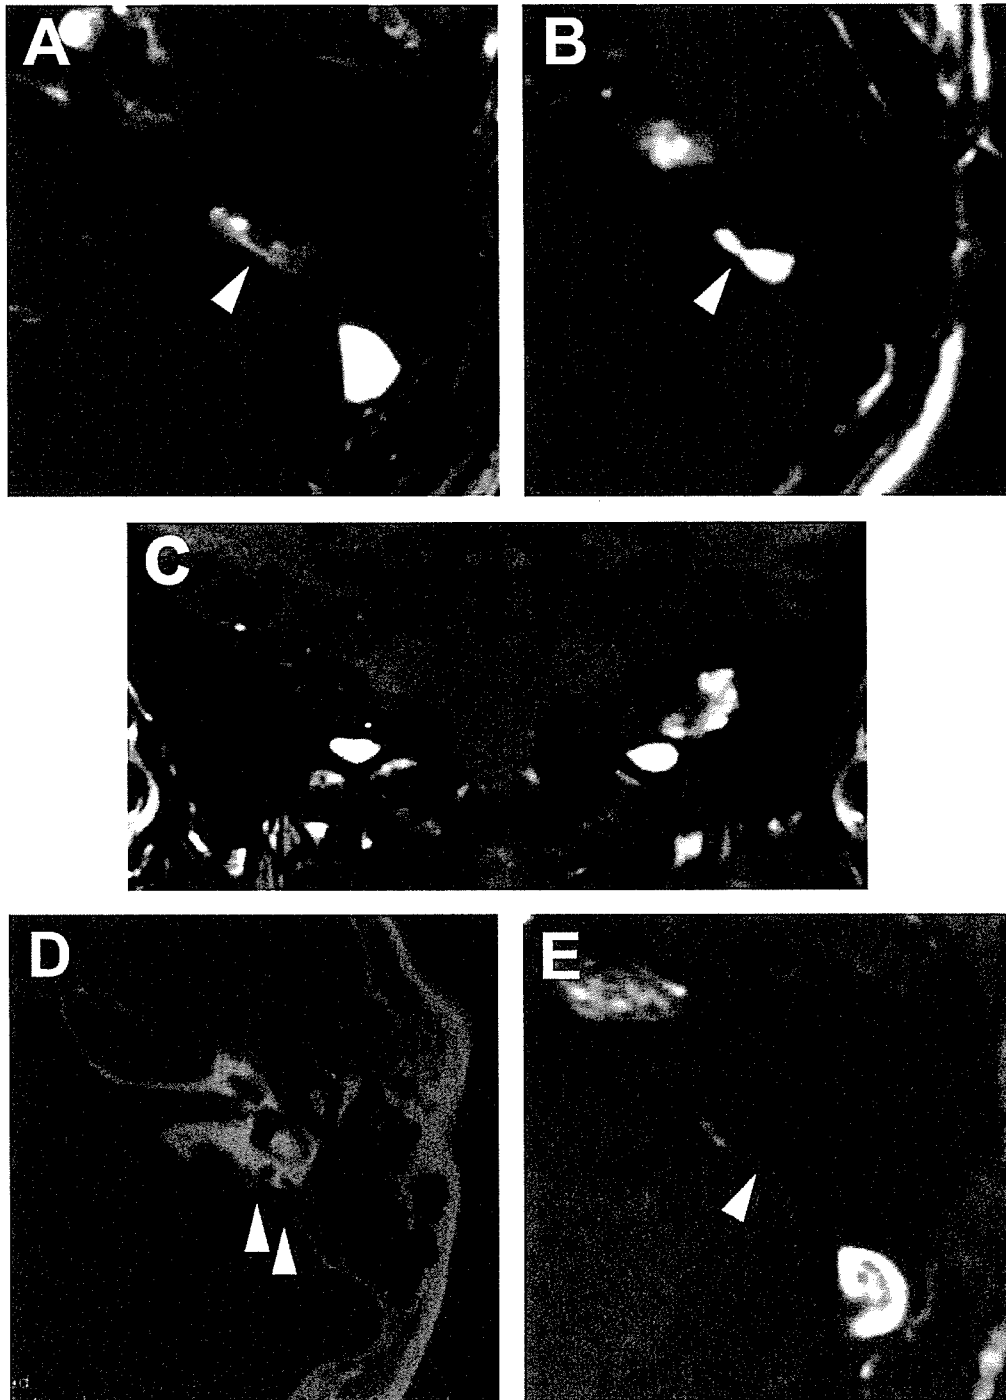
Magnetic resonance (MR) and computed tomography (CT) images of the tumor. Axial T1-weighted (A) and T2-weighted with FLAIR (B) MRIs reveal a hyperintense cholesterol granuloma (CG) (arrowheads) adjacent to the endolymphatic sac. (C) Coronal T1-weighted MRI shows the CG (arrowhead) with heterogeneous signal intensity. (D) Axial CT shows the CG (arrowheads) abutting the endolymphatic sac. (E) Axial T2-weighted MRI taken 6 months after surgical resection of the CG mass. Recurrence of the CG is not apparent (arrowhead indicates the part surrounding ES).
